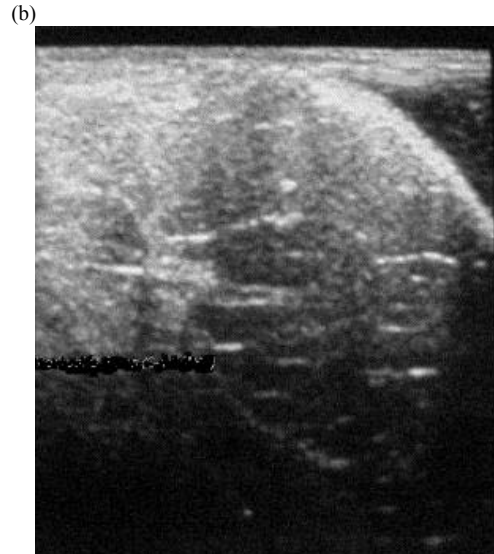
(a) the X-ray CT scan, (b) conventional B-Scan, (c) CURE US reflection image, (d) CURE US sound speed image.
